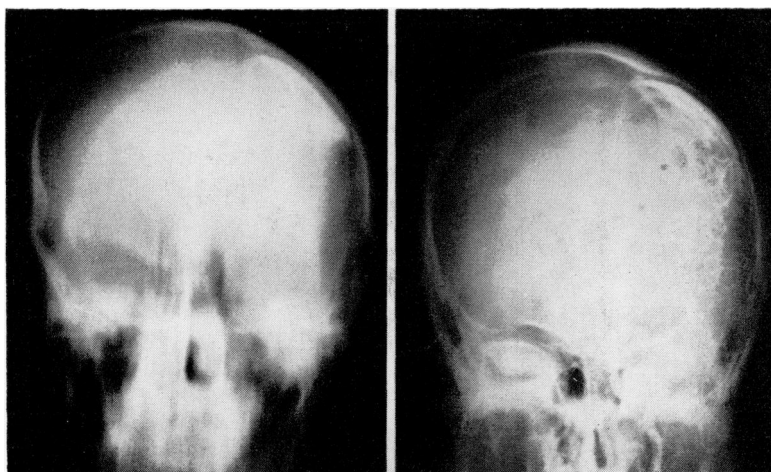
(left) Tomographic sectional radiograph of the skull reveals a separation of the calcific plaque from the inner table of the skull. The thickened dense overlying bone is also demonstrated and the asymmetry of the cranium is apparent.
